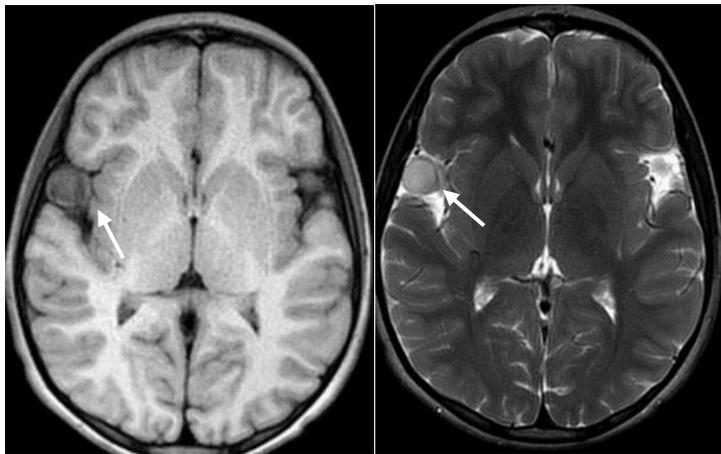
MRI in 2021 showing the regression of the venous aneurysm 17mm x 17mm, hypointense in T1 sequence (left) and hyperintense in T2 (right)
